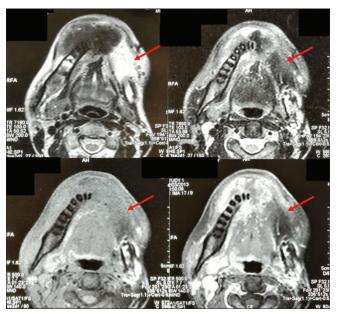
Magnetic resonance imaging image showing expansile lesion affecting the left hemimandible (red arrow)
